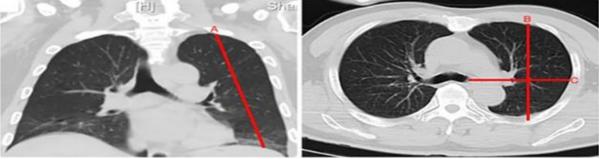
Measurement of lung volume in CT chest.
